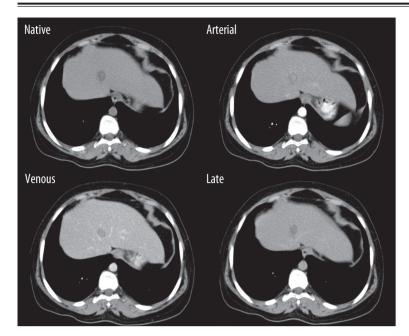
Patient T-J, CT performed in April 2006, axial slices before and after contrast media administration: in arterial, venous and late phases — lesion in liver segment 4.
